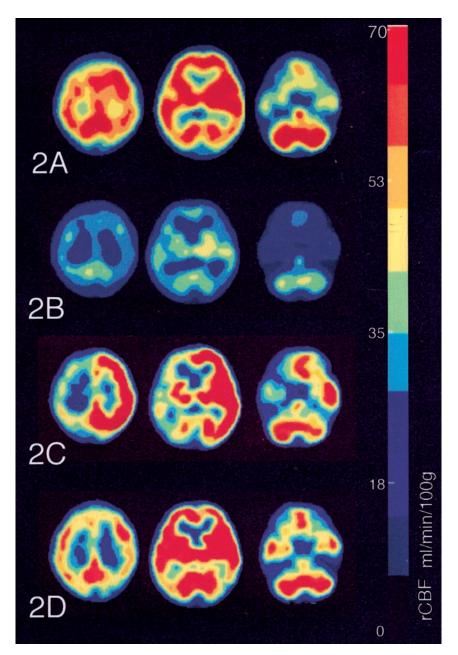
rCBF images at three different sections calculated by the I-123 IMP ARG method before the first course of chemotherapy (A), after the first course of chemotherapy (B), 2 hours after the recovery from the left hemiparesis (C), and 2 months before death (D) are shown. The same color scale is used to display quantitative rCBF images through four sequential I-123 IMP SPECT studies.
